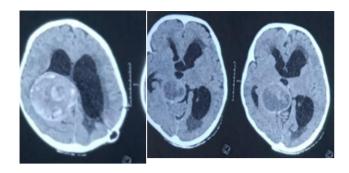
CT brain Plain showing the heterogenous mass lesion arising from the right posterior part of lateral ventricle with outside extension (shown by green arrow), having central mass (shown by blue arrow) and peripheral calcifications (shown by orange arrow) with obstructive hydrocephalus.
